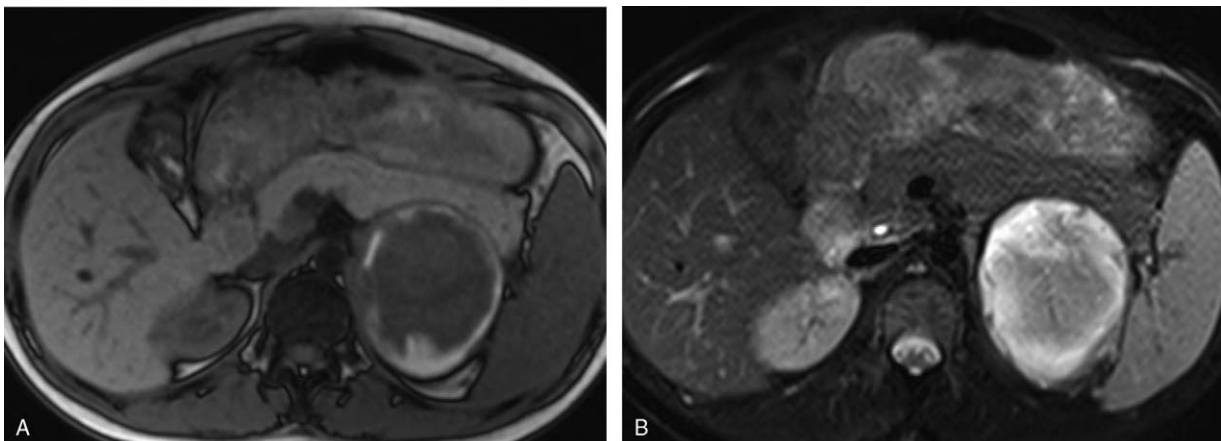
Repeat MR images at the 21 weeks of pregnancy. A, Axial T1-weighted image shows stable volume and signal as before. B, Axial T2-weighted image shows peripheral hyperintensity, and the edema around the mass was reduced. MR=magnetic resonance.
